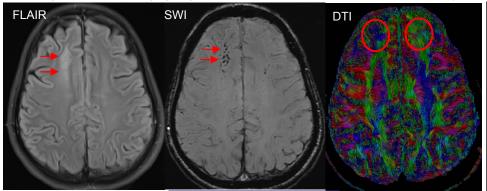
(Left). A traumatized brain manifests hyperintensities at right frontal white matter on FLAIR image (arrows), which is caused by edema, and hypointensities on SWI (arrows), which is caused by micro-hemorrhages.
